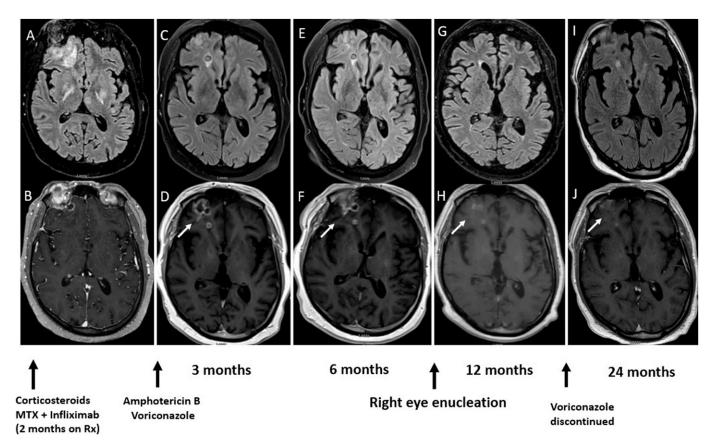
Axial T2/FLAIR MRI showing multiple brain parenchymal lesions most prominently in the right frontal lobe (A) and simultaneous enhancing lesions on axial T1-weighted MRI with gadolinium (B). Follow up at 3 months (C), (D), 6 months (E), (F), 12 months (G), (H) and 24 months (I), (J) showed significantly reduced but persistent enhancement despite treatment with voriconazole for two years.
